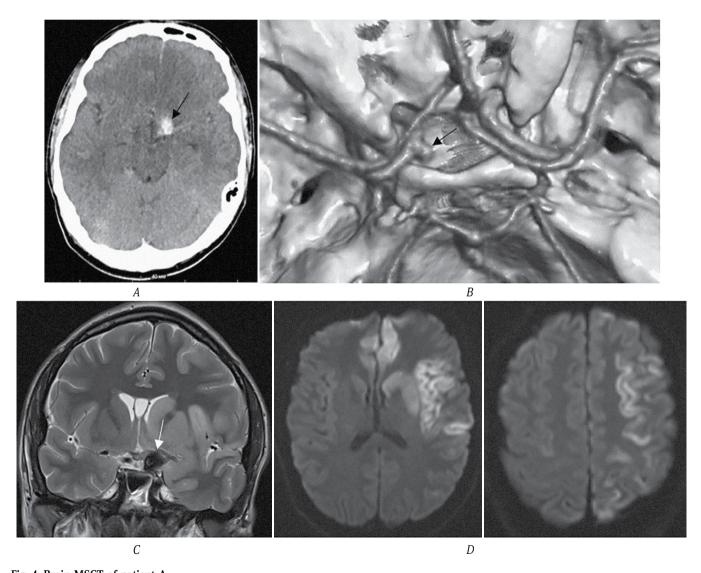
Brain MSCT of patient A. *A*, the arrow indicates the TA of the left ICA; *B*, MSCT angiography, 3D reconstruction, the arrow indicates the functioning part of the aneurysm of the left ICA; *C*, brain T1-WI MRI, the arrow indicates the TA of the left ICA; *D*, MRI in DWI mode, areas of acute ischemia in the subcortical structures of the left brain hemisphere.
